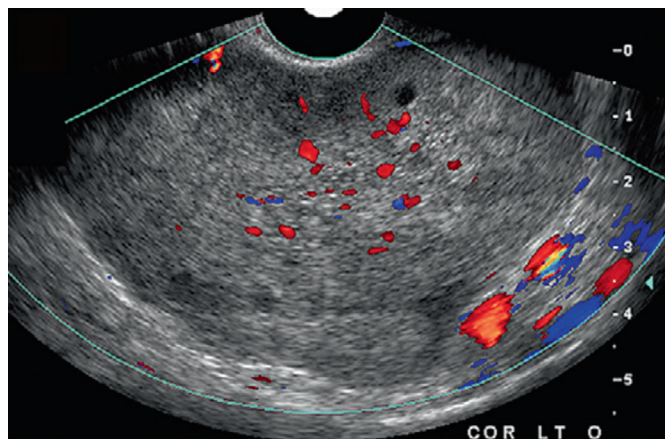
Ovarian torsion with color Doppler image demonstrating venous and arterial flow. (From Cicchiello LA, Hamper UM, Scutt LM: Ultrasound evaluation of gynecologic causes of pelvic pain. *Obstet Gynecol Clin North Am* 38:85–114, 2011.)
